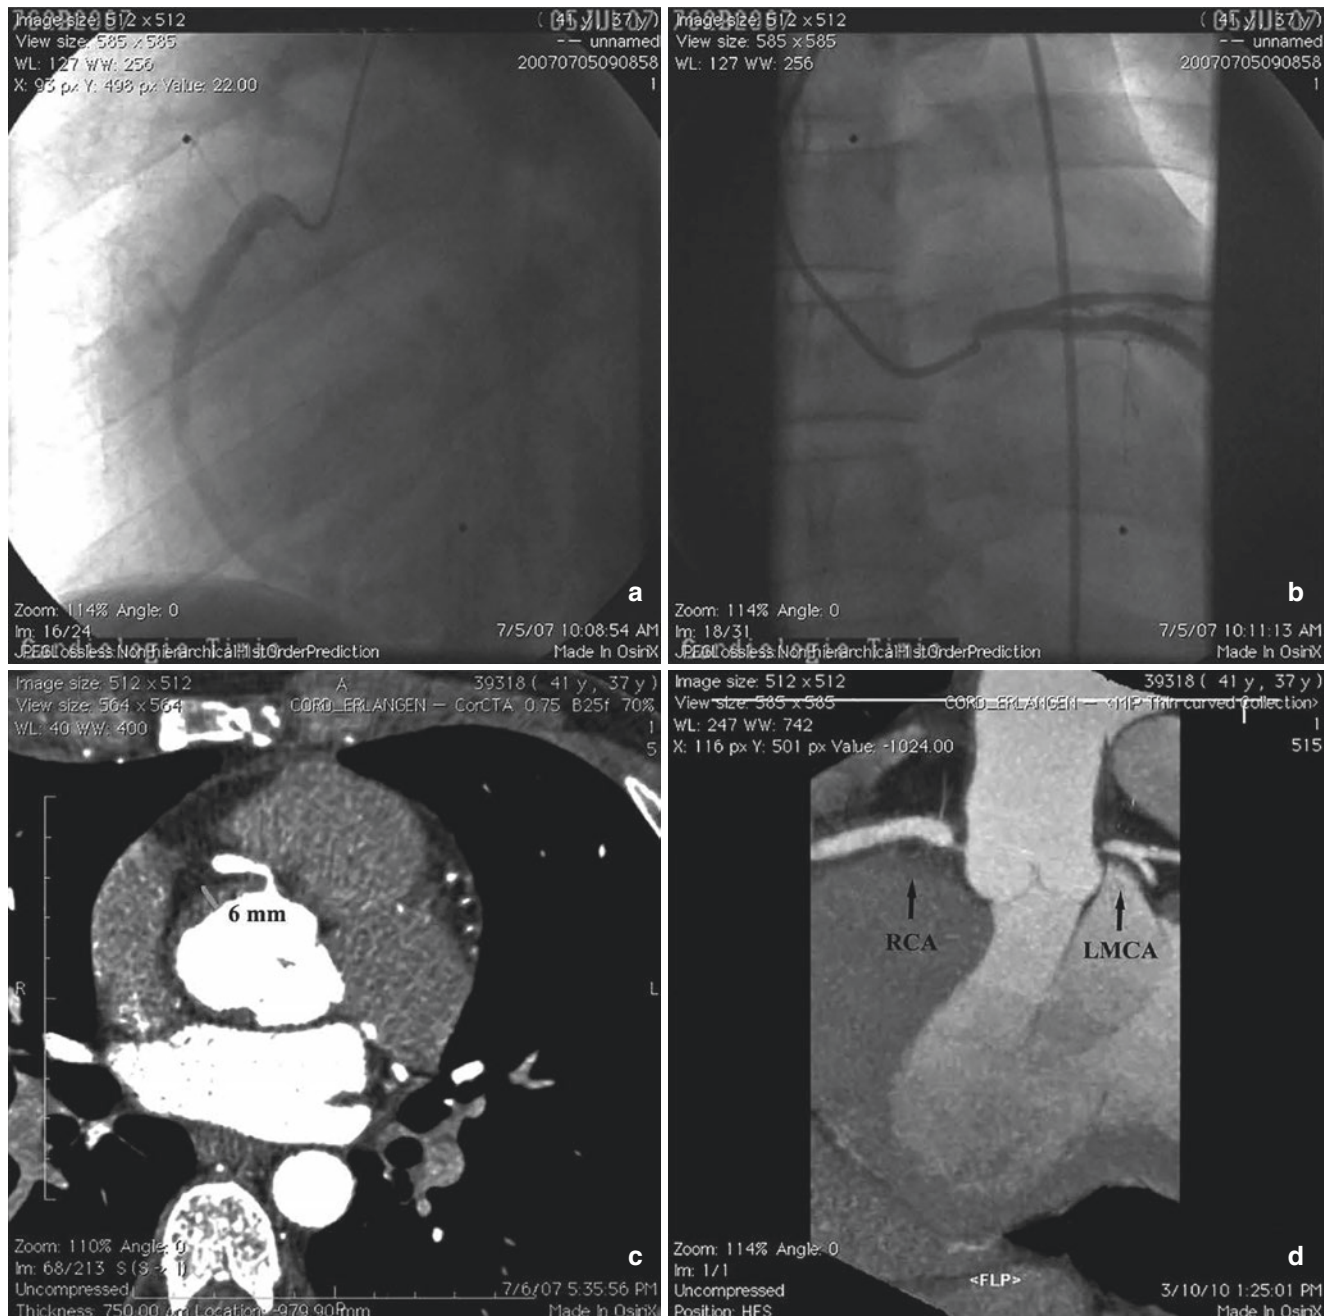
Images from a patient with syphilis. (a, b) Coronary angiography showing ostial stenosis of the right (a) and left (b) coronary arteries. (c) Computed tomographic scan revealing a thickened aortic wall (6 mm), an irregular intima at the level of the aortic root, and right
